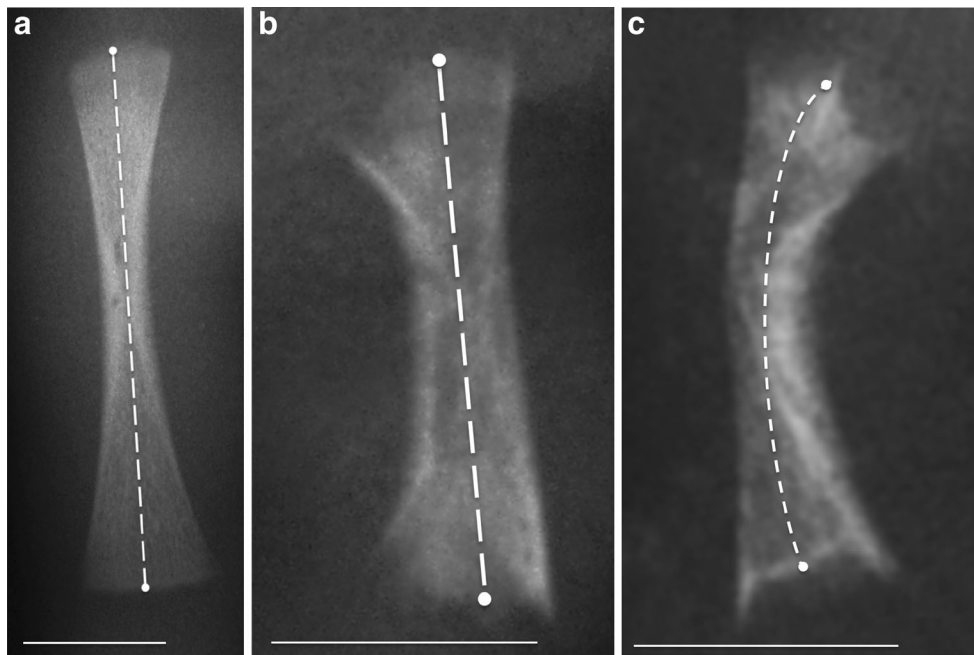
a Control femur X-ray (gestational age 16 weeks). Method of measurement of the ossified diaphysis (*bar*=10 mm). b TD straight femur X-ray (gestational age 21 weeks). The ossified diaphysis is shorter than that of control and with an irregular structure of the cortex. The mid-shaft is enlarged by periosteal apposition around the diaphysis. The original shape of the diaphyseal ossification nucleus can be distinguished within
